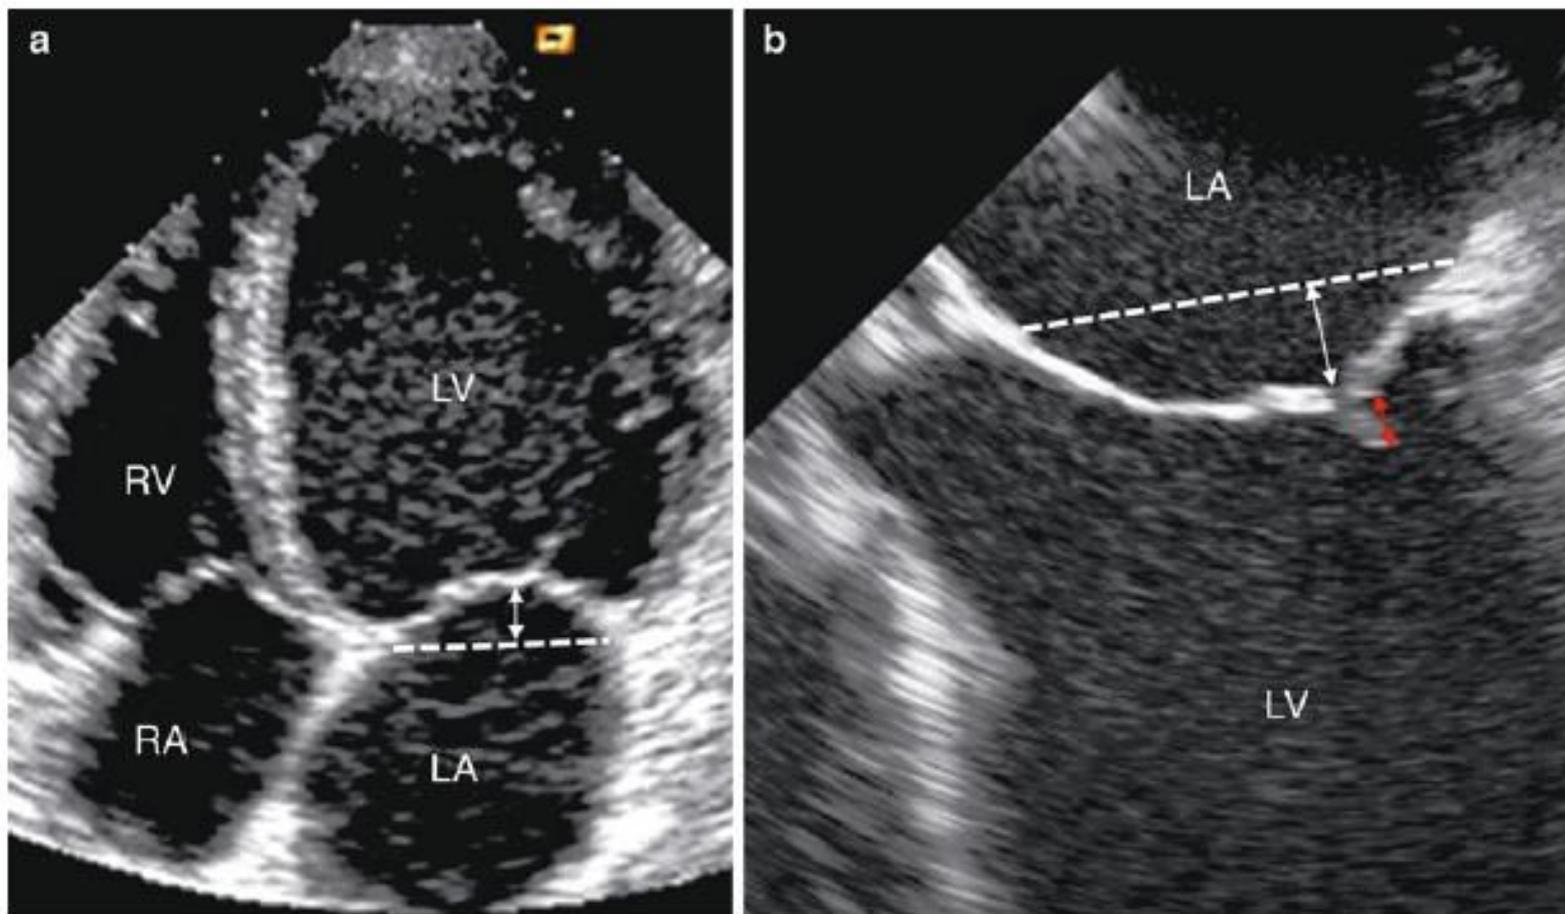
a Four-chamber transthoracic apical view in a patient with non-ischemic dilated cardiomyopathy. Classical conformation with a “symmetrical tent” due to dislocation of both papillary muscles. Measurement of the tenting height. The height of tenting is measured (double-headed arrow). b Magnified transesophageal
